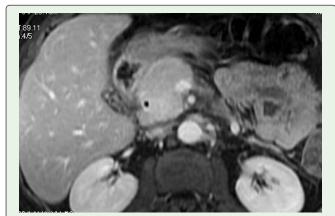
T1 enhanced axial MRI showing the enhancement of the CBD wall.
